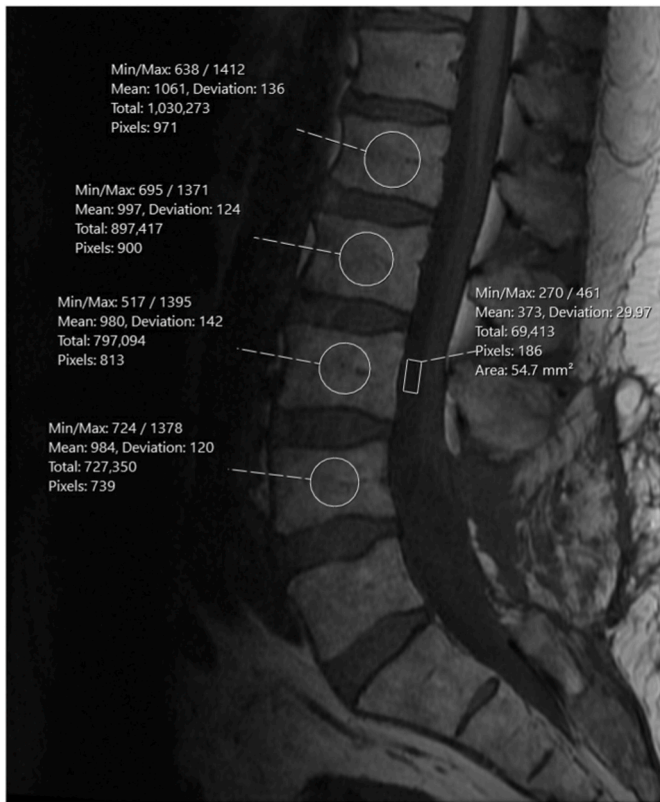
Sagittal T1-weighted MRI showing regions of interest for VBQ measurements in a 60 y/o female patient. To calculate the VBQ score, the median signal intensity (SI) of the medullary portion of the vertebrae L1-L4 was divided through the SI of the cerebrospinal fluid (CSF) at L3.
